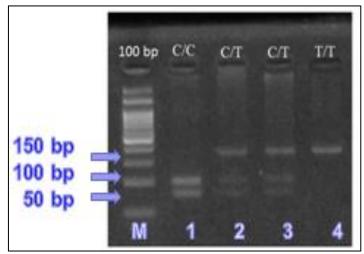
Representative of an agarose gel electrophoresis of PCR partial products of HIF1 gene. Lane 1; CC genotype (100 and 50 bp) and lanes 2, 3; CT genotype (50, 100 and 150 bp) and lane 4; TT genotype (150bp). Lane M is DNA 100 bp ladder.
